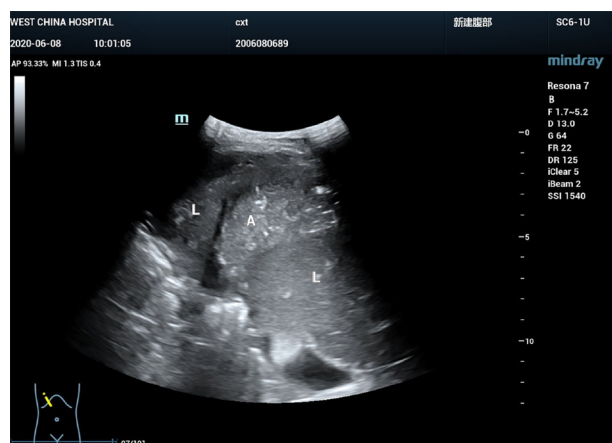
B-mode ultrasound displayed a right subphrenic mass with heterogeneous echo. L: Liver; A: Abscess.
